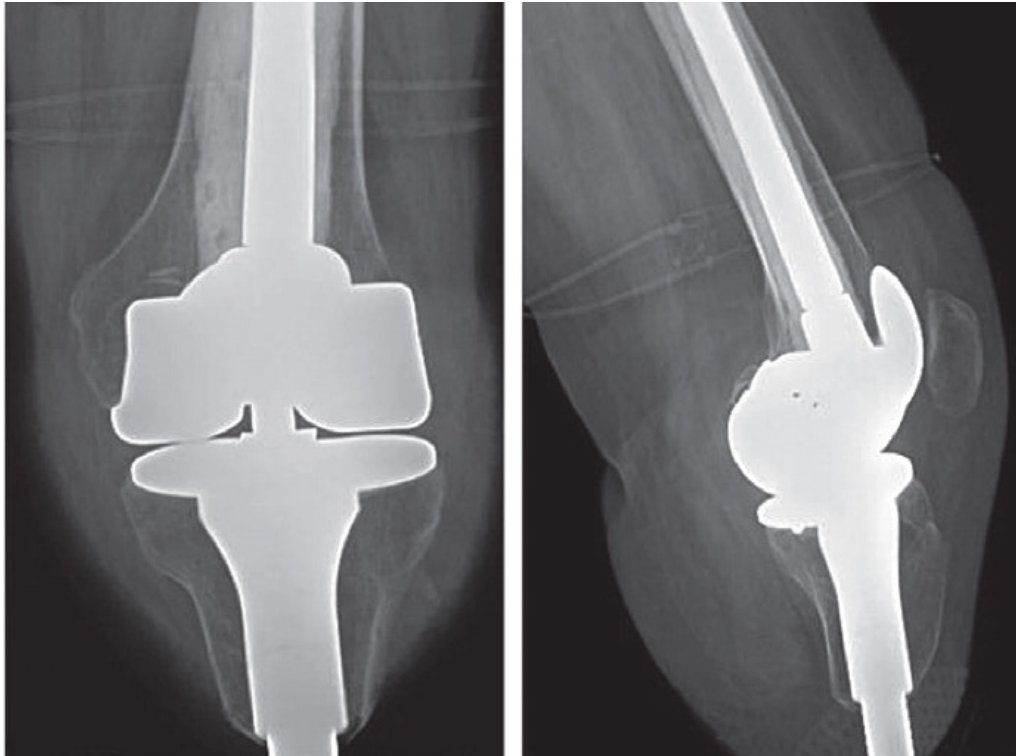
AP and lateral radiographs of a patient who has a total knee arthroplasty connected to a tibial osseointegration prosthesis. Reproduced with no permission necessary from Khemka A, Frossard L, Lord SJ, Bosley B, Al Muderis M. Osseointegrated total knee replacement connected to a lower limb prosthesis: 4 cases. *Acta orthopaedica*. 2015 Nov 2;86(6):740-4.
